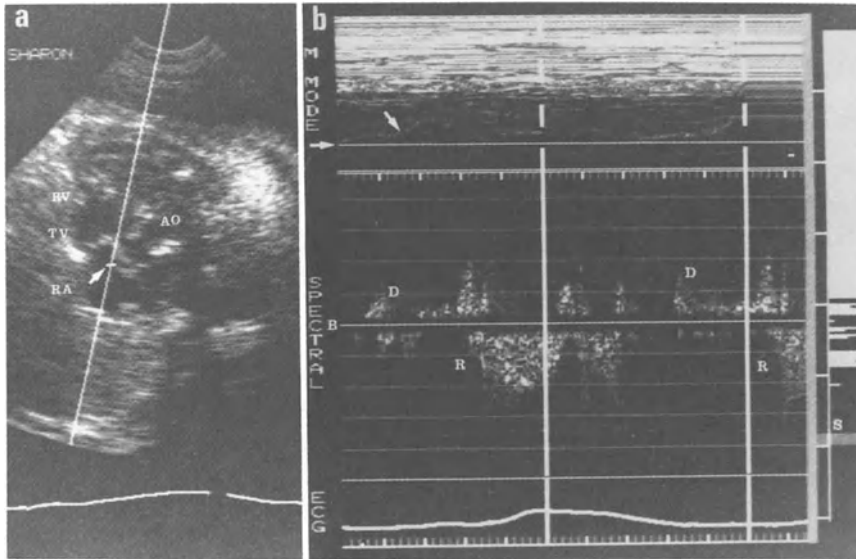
Doppler identification of tricuspid regurgitation in a fetus with complete heart block and heart failure. (A) The Doppler sample volume (oblique arrow) was placed in the right atrium (RA) imaged in the aortic (AO) short-axis plane. (B) The Doppler tracing showed prominent reversed flow (R) during systole indicative of tricuspid incompetence. Normal flow patterns were seen during diastole (D). The M-mode echocardiogram (oblique arrow) was used to time the diastole and systolic phases of the fetal cardiac cycle. The horizontal arrow denotes the position of the Doppler sample volume on the M-mode. (B, Doppler baseline; TV, tricuspid valve.) (Source: Reprinted with permission from Maulik D, Nanda NC, Saini VD, Thiede HA. Application of Doppler echocardiography in the assessment of fetal cardiac disease. *Am J Obstet Gynecol.* 1985;151:951-956.)
